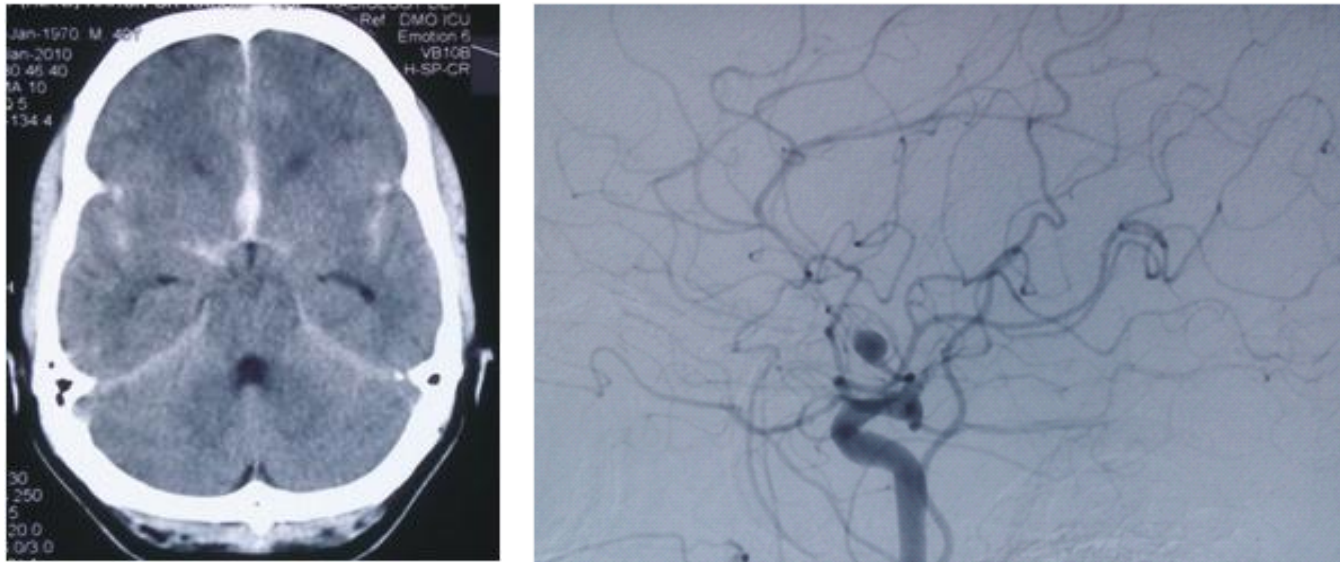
Non contrast CT Scan of Brain revealed SAH. DSA depicts ruptured Acom aneurysm
